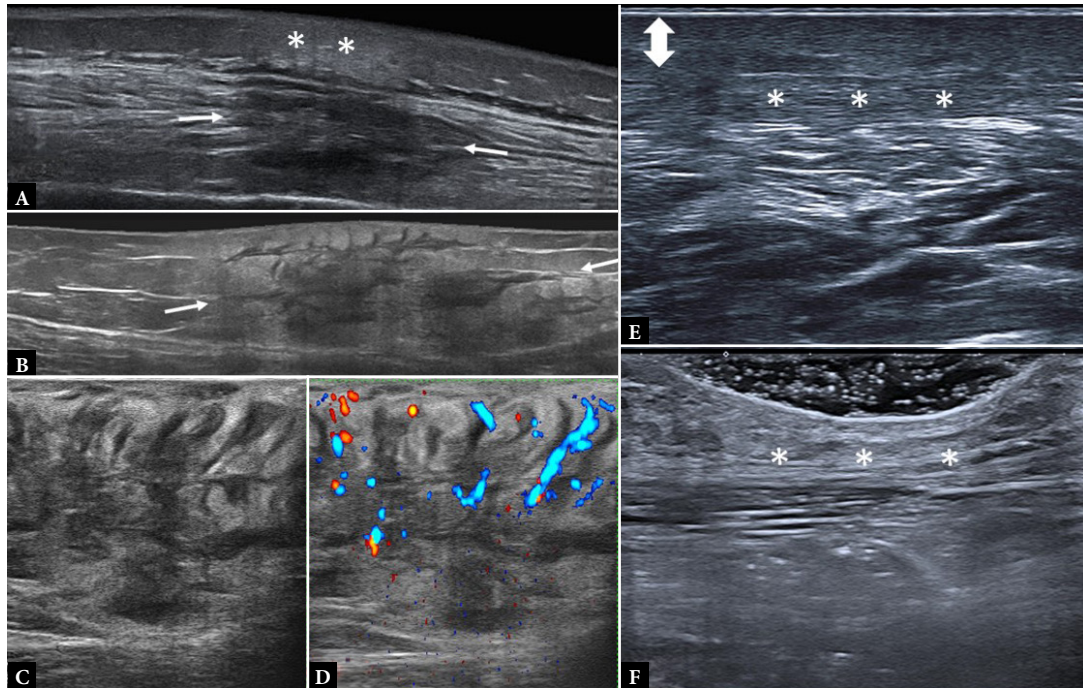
Morphea. Inflammatory phase: A. Extended field-of-view image of the lateral aspect of the leg, showing a lobular panniculitis sonographic pattern in the subcutaneous tissue (*) with muscular regional involvement (white arrows); B. Extended field-of-view image showing a mixed panniculitis sonographic pattern involving the entire thickness of the SAT at the lateral aspect of the thigh; C, D. Same case: B-mode and Power Doppler axial sonograms demonstrating a septal panniculitis pattern with septal hyperemia. Sclerotic phase: E. Increased thickness of the hypochoic dermis (doble arrow) with thinning of the hypodermis and a fibrillar pattern (*); F. Atrophic phase: normal dermis and severe hypodermis thinning; note the absence of fatty lobules (*)*
